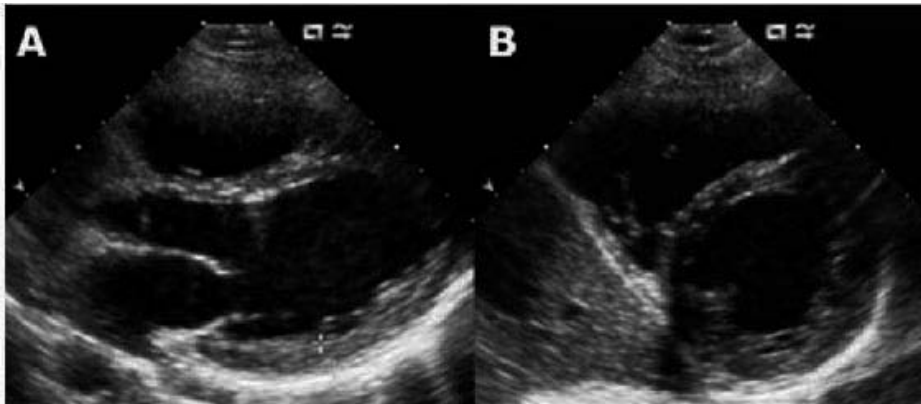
Echocardiogram 5 days after admission. Parasternal long axis view (A) and short axis (B) in diastole. Normalization of the myocardial thickness in the posterior wall and posterior papillary and resolution of the pericardial effusion can be seen. Adapted from reference 38 with permission.
